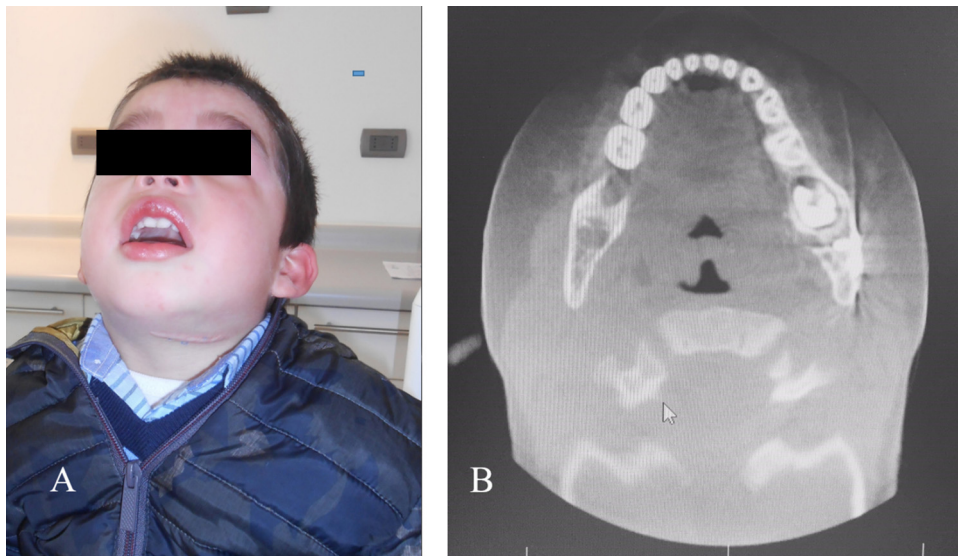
A. Clinical aspect one year after surgery. B. CT image, without signs of recurrence, one year post-surgery.
